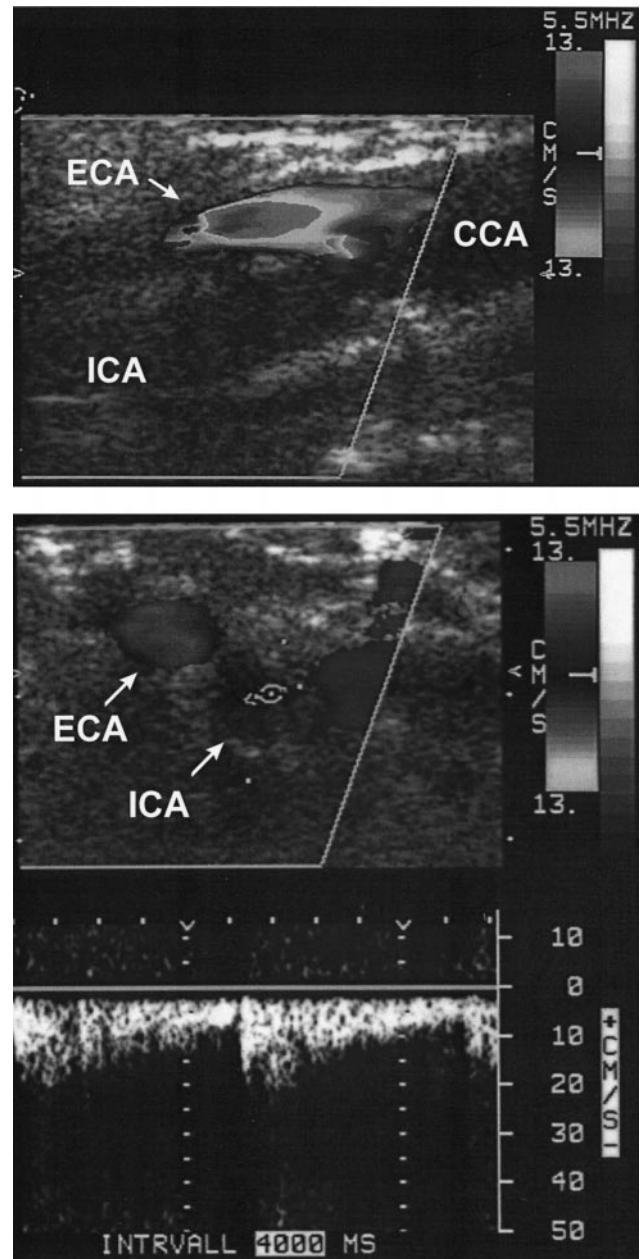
Patient 15. Contrast-enhanced ultrasound did not show any flow in this ICA, which was presumed to be occluded (Top, longitudinal section) but was subtotally stenosed on arteriography. After the result of a CT angiography that revealed flow in the very distal submandibular ICA, we were able to confirm this finding on a very distal submandibular transverse section using echocontrast (Bottom). This was unnoted in the first ultrasound investigation. Below the B-mode scans are the corresponding pulsed-wave Doppler spectra. CCA indicates common carotid artery; ECA, external carotid artery.
